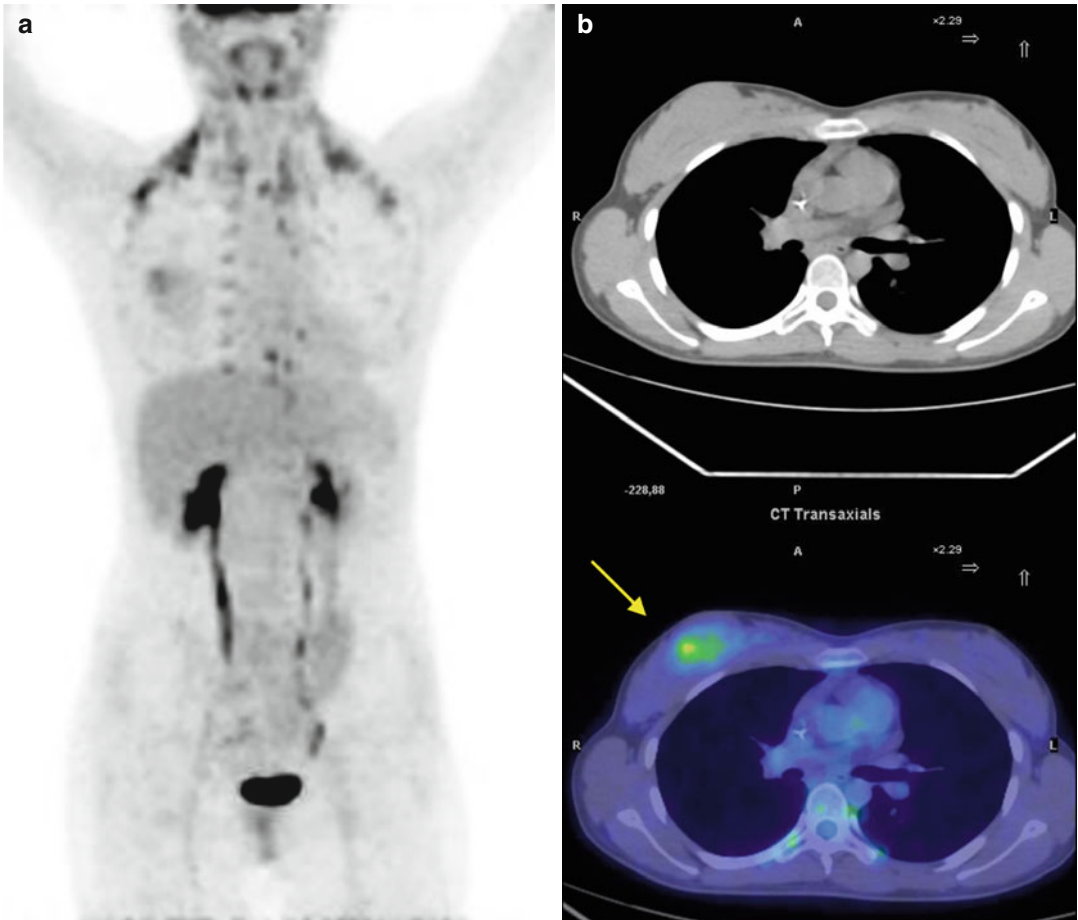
A 14-year-old girl treated for Hodgkin's lymphoma. Maximum intensity projection (a) and axial CT and PET/CT fusion images (b) show moderately intense
